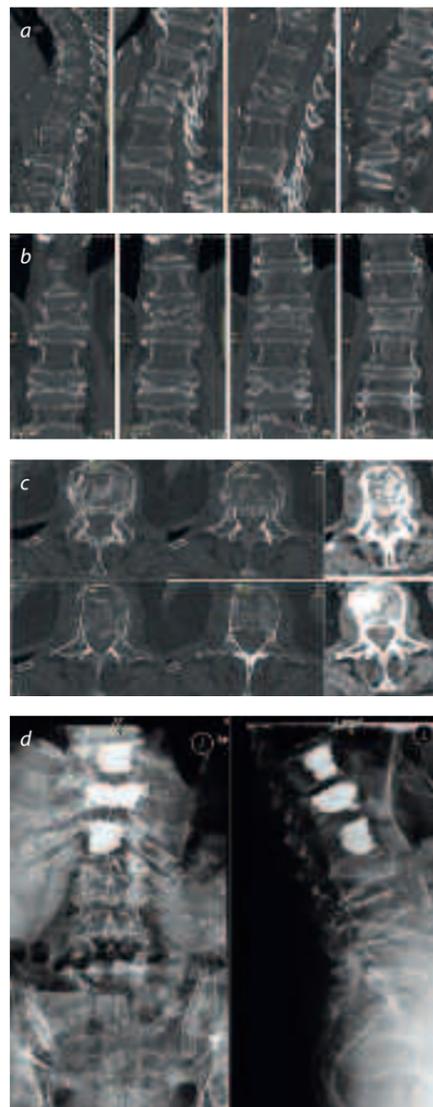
This 88-year-old lady presented with immobilising back pain. She lives by herself on a farm, taking care of her 60-year-old daughter who is mentally disabled. The patient is treated with Fentanyl TTS without significant effect. She is furthermore under cumarine, due to a cardiac arrhythmia. She has had osteoporosis treatment for 4 years. The preoperative CT scan demonstrates a situation with multiple fractures, of which L1 is a fresh lesion with a complex fracture pattern (a, b). There is posterior wall involvement with a spinal canal narrowing (which was not clinically apparent) (c). Based on the preoperative imaging, a discussion was launched whether simple cement reinforcement is possible or an internal fixation with cemented screws and cementing of the deficient anterior columns is necessary and would be more appropriate. For a simple vertebroplasty procedure, there were concerns of immediate cement leakage and thus an insufficient stability. The stent might be the better solution, as one can re-align the fragments by its expansion and this would allow a better filling of the vertebral body. Therefore the patient was informed to have either a percutaneous stentoplasty procedure or perhaps even an open intervention, and was put in general anaesthesia for this procedure. A stentoplasty procedure with two large stents that were expanded to its maximum allowed the vertebral body to expand and provided a solid frame for the cement injection. It was possible to fully support the vertebral body and therefore no additional stabilisation was carried out. The filling volume was 10 cc of PMMA, in addition the adjacent vertebrae were prophylactically treated by a vertebroplasty procedure (d). The patient was referred for rehabilitation two days after the procedure and was due to return home after a further 2 weeks with the support of the community nurse.
